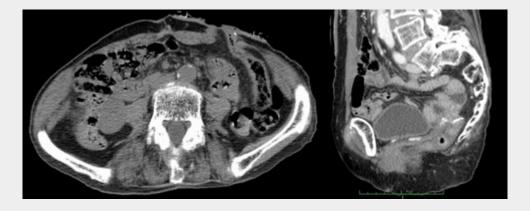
CT findings of the Hartmann procedure include left flank colostomy and a closed rectal stump (note the surgical staples).
